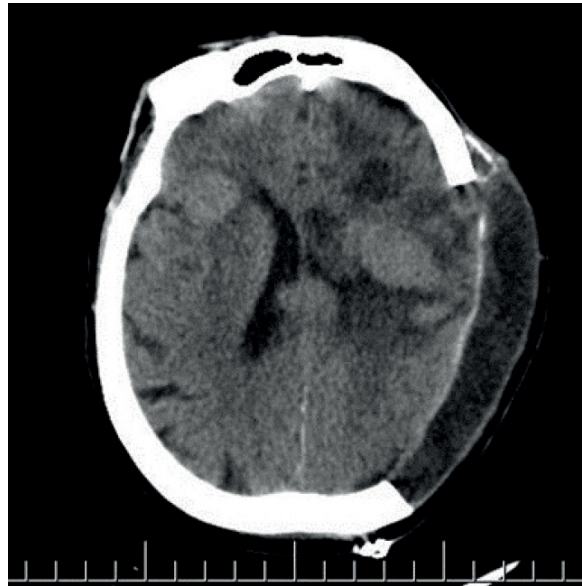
CT image of brain showing hematoma masking the tumor
